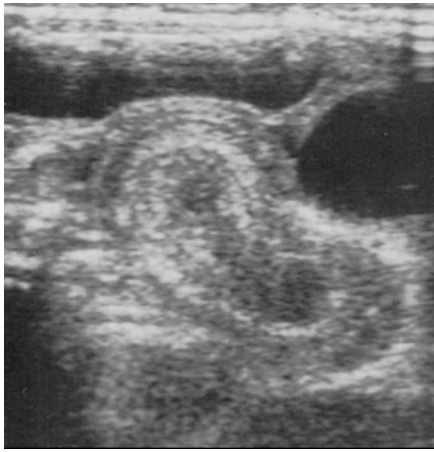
Ultrasound scan showing the doughnut appearance (target lesion) of an intussusception.
